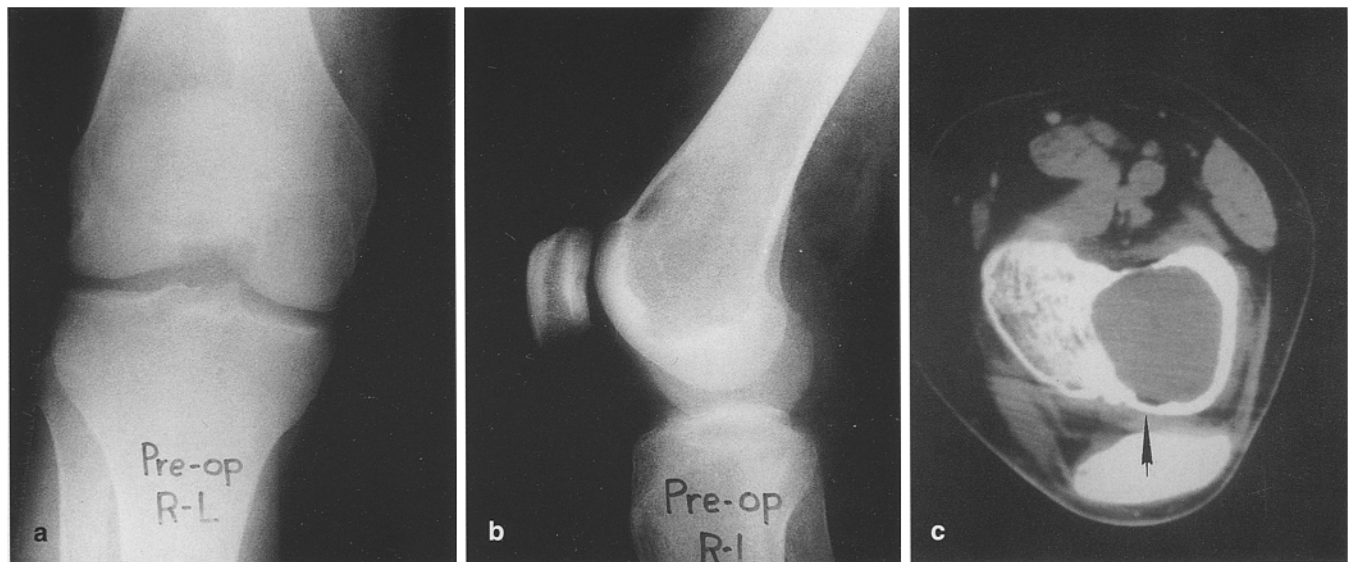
Radiograph of the osteolytic lesion of the distal left femoral metaphysis
